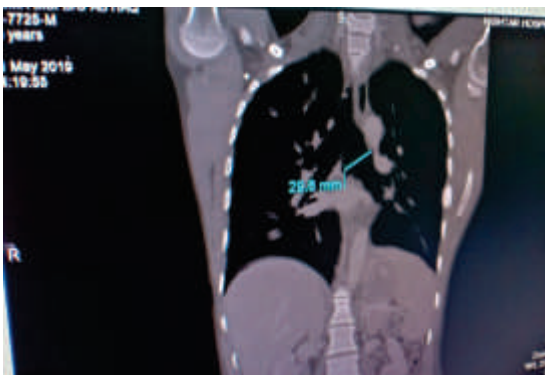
CT thorax with MPR shows right mainstem bronchus diameter as 2.63cm
